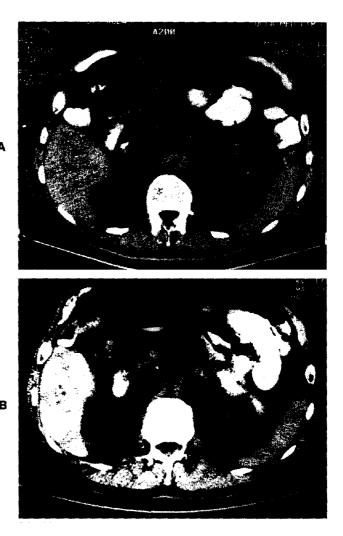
A, CT scan from a patient with unresectable pancreatic cancer prior to the initiation of chemotherapy. There is involvement of the superior mesenteric vein by tumor. B, CT scan from the same patient after 7 months of chemotherapy. The tumor has markedly decreased in size and no vessel involvement is apparent.
